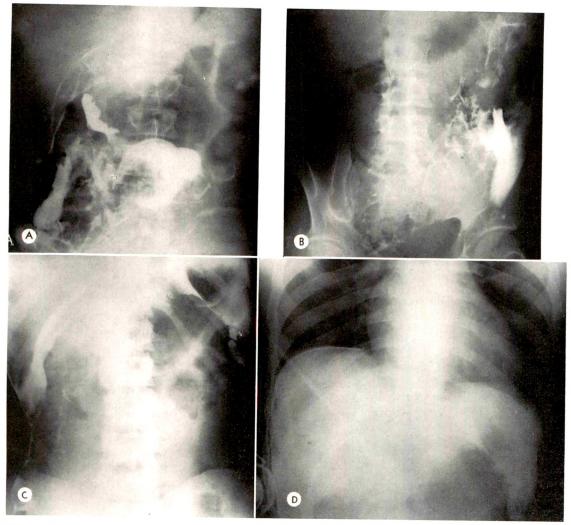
(A) Anteroposterior roentgenogram of the abdomen in recumbent position demonstrating a large quantity of contrast material in the peritoneal cavity, outlining the large and small bowel and the under surface of the liver and (B) the splenic flexure. (C) Contrast material outlining the right lateral peritoneal reflexion and undersurface of the liver and (D) contrast material around the liver as well as the spleen and splenic flexure of the colon.
